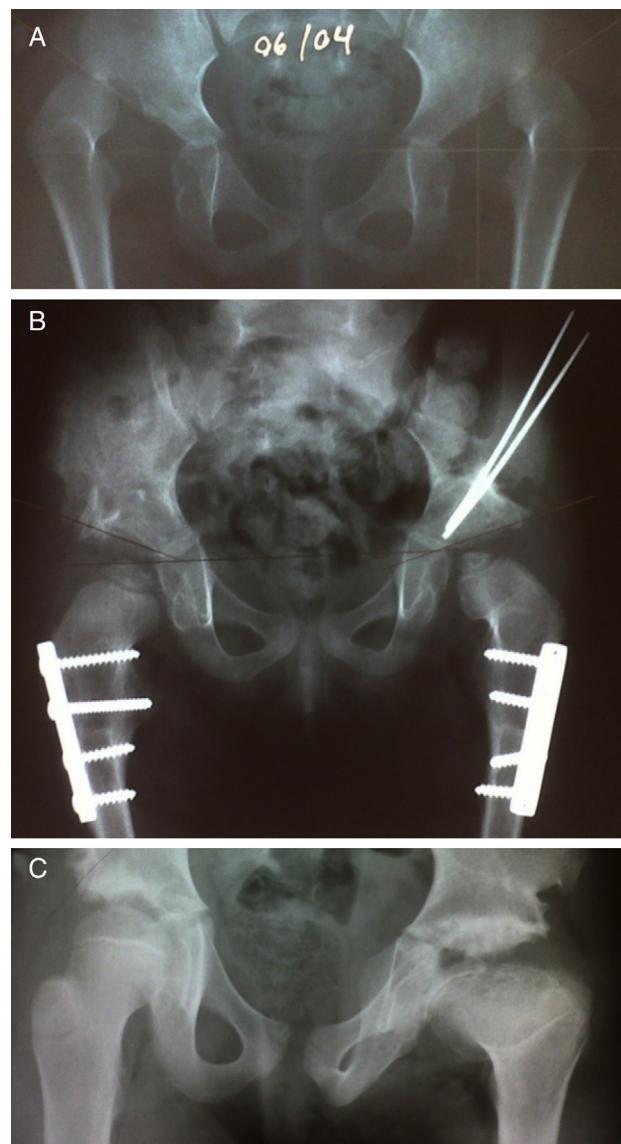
Female patient aged three years and three months: preoperative X-ray in June 2004 (A). X-ray in January 2005, three months after operation on left hip and six months after operation on right hip (B). X-ray in October 2011, in the late postoperative period, seven years and nine months after operation on right hip and six years and nine months after operation on left hip, presenting type 4 necrosis of the femoral head (C).
